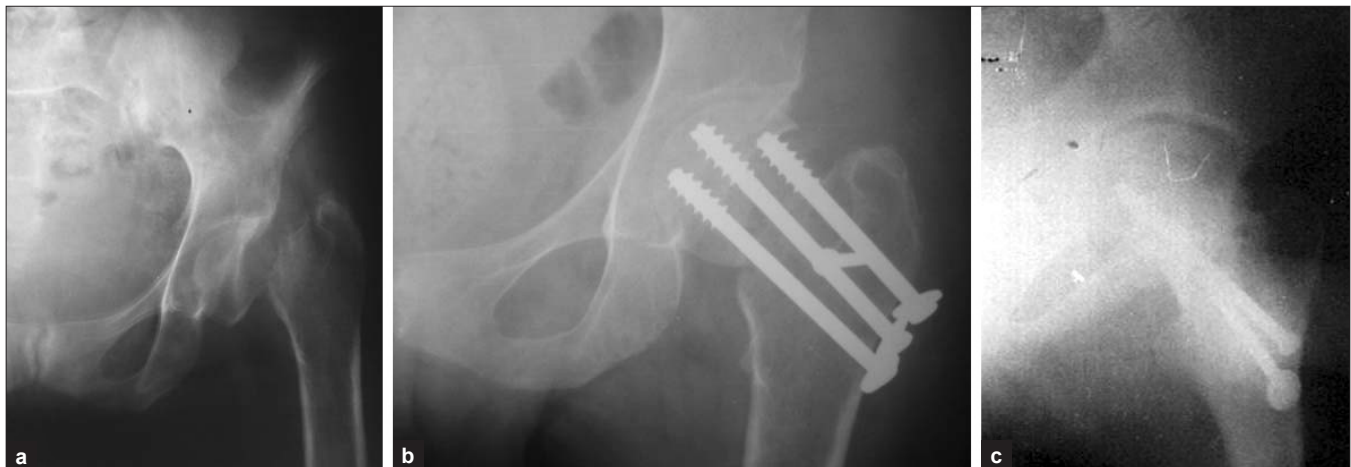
X-ray left hip joint anteroposterior view showing (a) 81 days old ununited femoral neck fracture (b) immediate postoperative X-ray (c) 2.5 years followup
